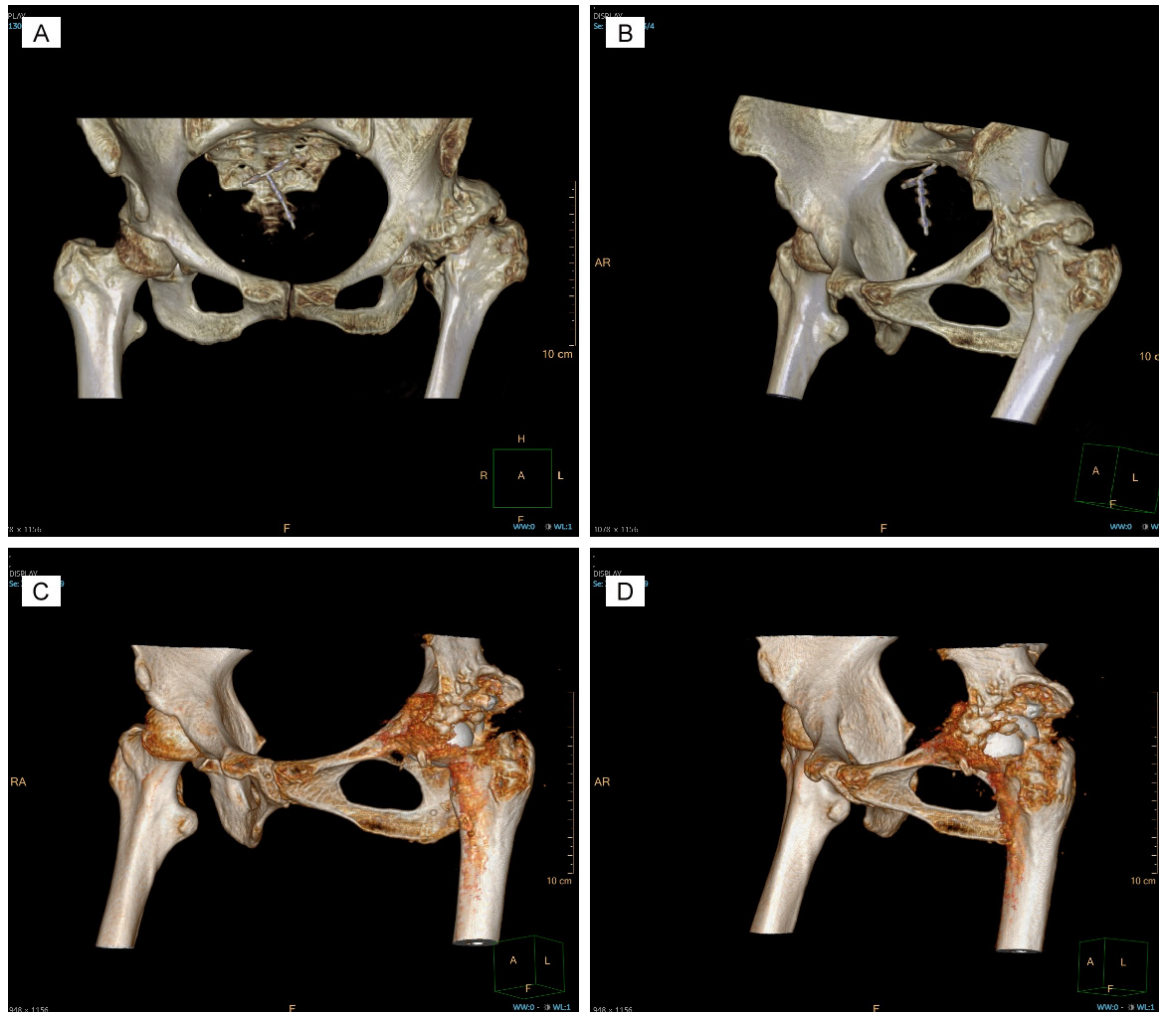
Three-dimensional reconstruction of the patient's pelvic model. A, B. Preoperative 3D CT images showed acetabular dysplasia characterized by relatively intact margins, a shallow acetabulum, and mild retroversion, consistent with the typical manifestations of Crowe type II/III DDH. C, D. Postoperative 3D image showed reconstruction of the right acetabulum using autologous femoral head structural bone grafting. The graft significantly improved the bone defect in the superolateral acetabular region, significantly enhancing coverage and providing a stable basis for the acetabular prosthesis. Note: CT, computed tomography; DDH, developmental dysplasia of the hip.
